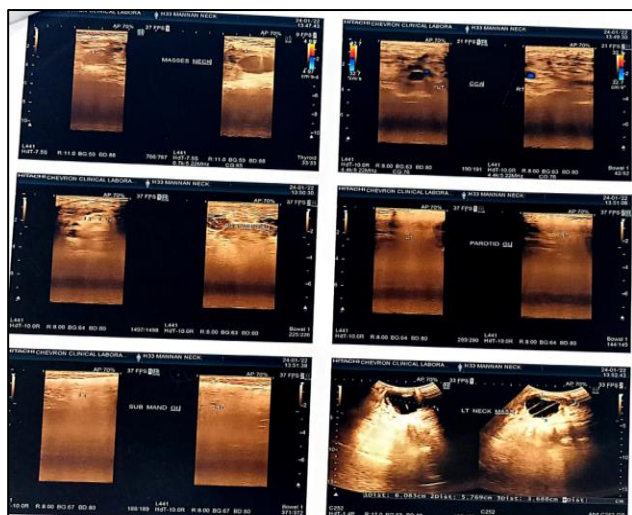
Ultrasound of both neck on 23rd January 2022.
